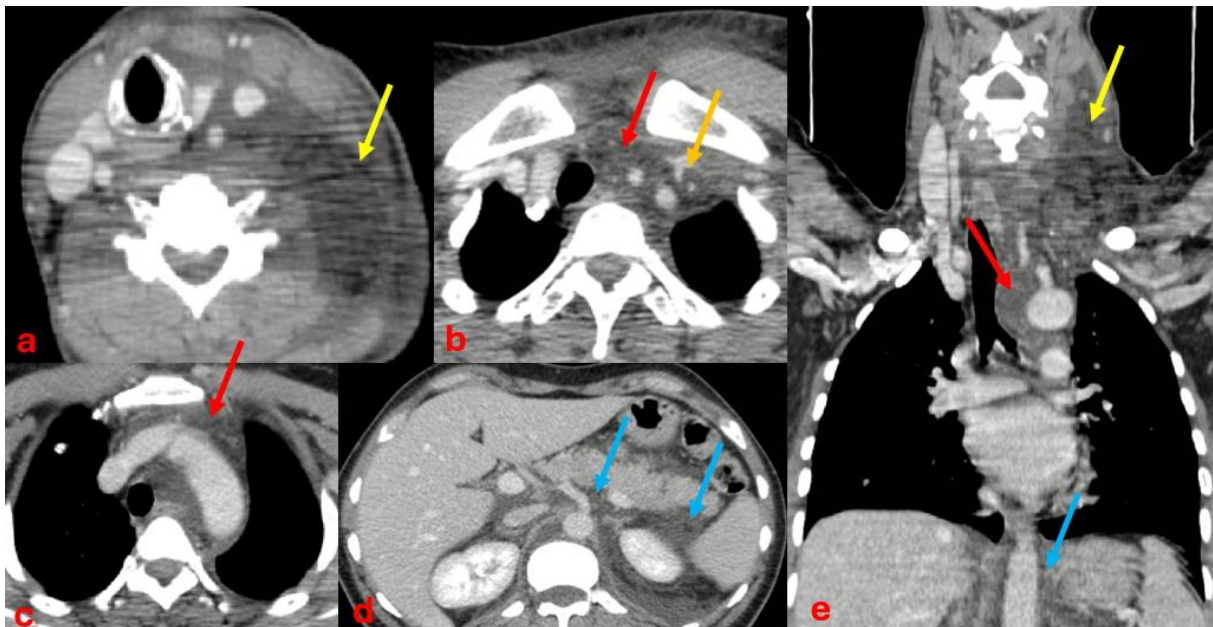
Axial contrast-enhanced CT images of the cervicothoracic region and upper abdomen (a–d), with coronal reconstruction (e), using intravenous iodinated contrast, demonstrate extensive left laterocervical cellulitis associated with marked inflammatory fat stranding (yellow arrows). Notably, the infectious process extends inferiorly beyond the cervicothoracic junction into the mediastinum (red arrows) and further tracks into the retroperitoneum (blue arrows). Additionally, a small venous thrombosis is identified involving the proximal left internal jugular vein and the left subclavian vein (orange arrow).
